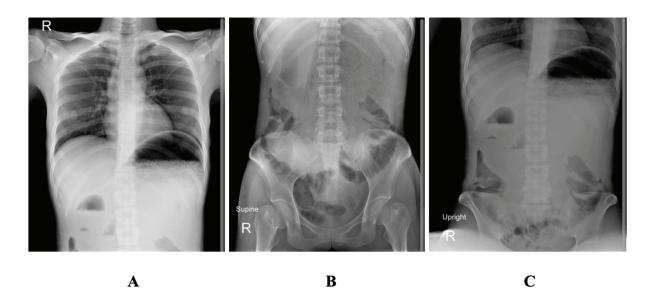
Acute abdomen series revealed gastric distention extending to the lower abdomen, with no evidence of small bowel dilatation or pneumoperitoneum (A) Chest x-ray (B) Supine (C) Upright
